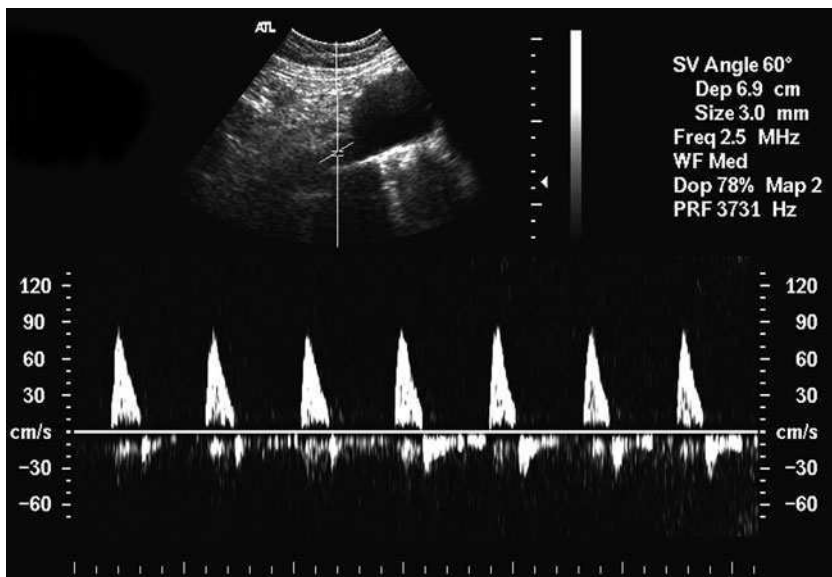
Doppler ultrasound waveforms acquired proximal to an AAA. (Reprinted from: [29]; with permission from Edinburgh University Library)
